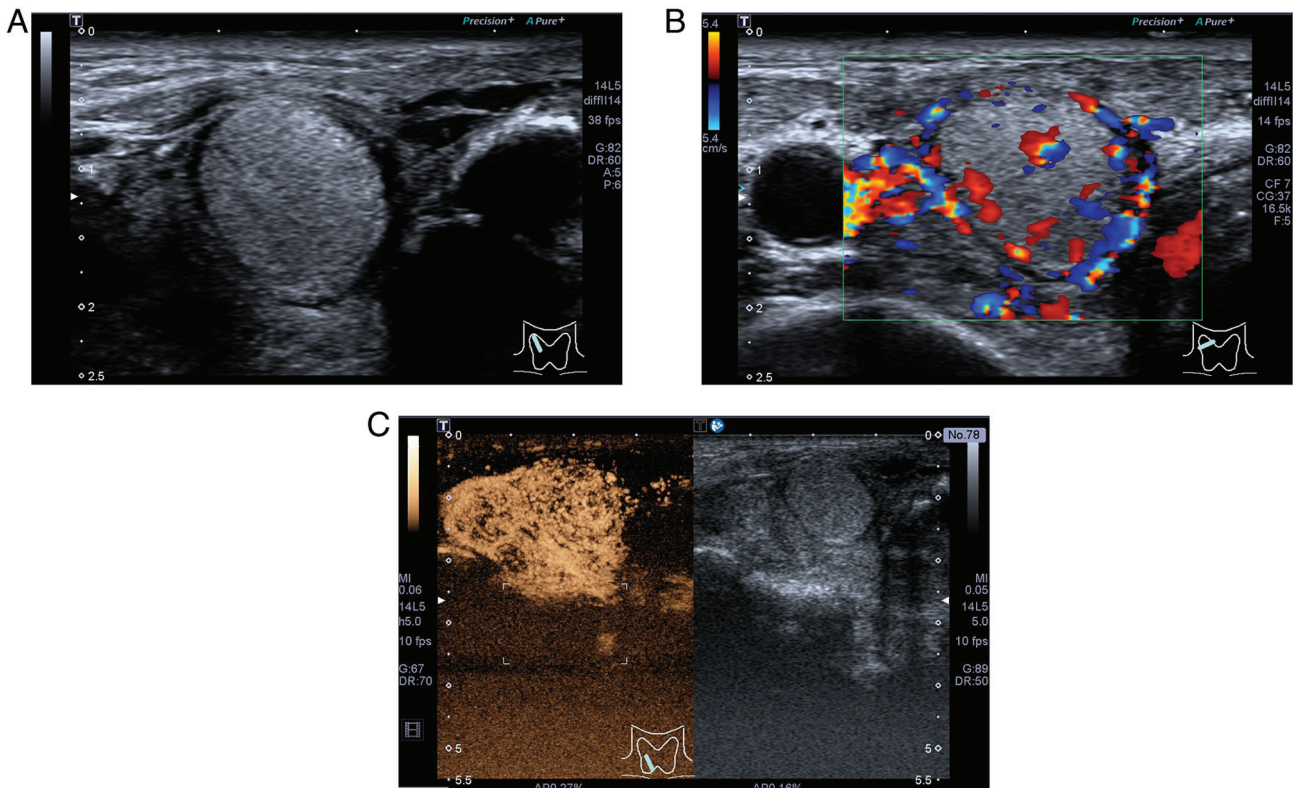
Combined US and CEUS findings of Lesion B after treatment. (A) US revealed that the boundary was clearer, and a uniform and continuous hyperechoic thin halo was present in the periphery. (B) Color Doppler flow imaging showed an increase in the internal blood flow signal of the nodule, and the periphery appeared to have a circumferential blood flow signal. (C) CEUS showed a uniformly high enhancement of the nodule with clearer boundaries. US, ultrasound; CEUS, contrast-enhanced US.
